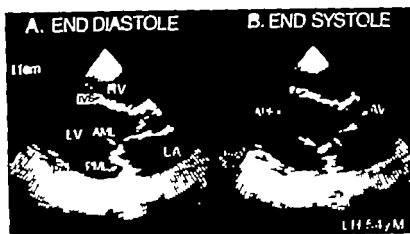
Cross-sectional echocardiograms from Case 4. Note a markedly dilated left atricular cavity (LV) with diminished contractility. There is no appreciable change in atricular configuration from end-diastole to end-systole. At end-diastole (left), the point of mitral valve coaptation is displaced inferiorly toward the entricular apex. During systole, the normal motion of the mitral valve toward the left atrium is not observed, and the point of coaptation remains inferior and displaced towards the apex of the ventricle at end-systole (large arrow in the right panel). In addition, basal part of the anterior mitral leaflet (AML) appears as a convex curve towards the left atrium (small arrow in the right panel).
